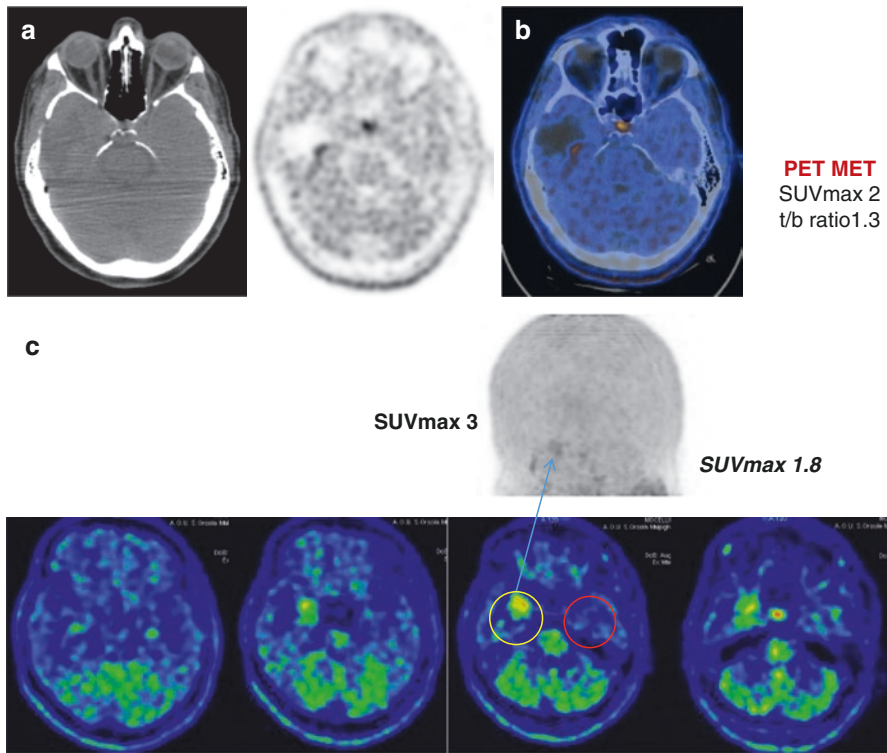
(a–c) Axial CT (a), MET/PET (b) and axial fused PET/CT (c) show increased uptake in the residual tumour in the right temporal lobe. Bottom images show the differences in uptake in the tumour region and in the contralateral normal lobe.
